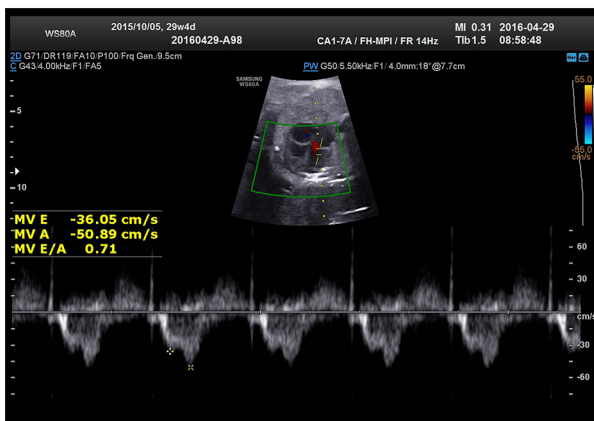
Ultrasound Doppler spectrum of fetal MV in the placenta previa group.
